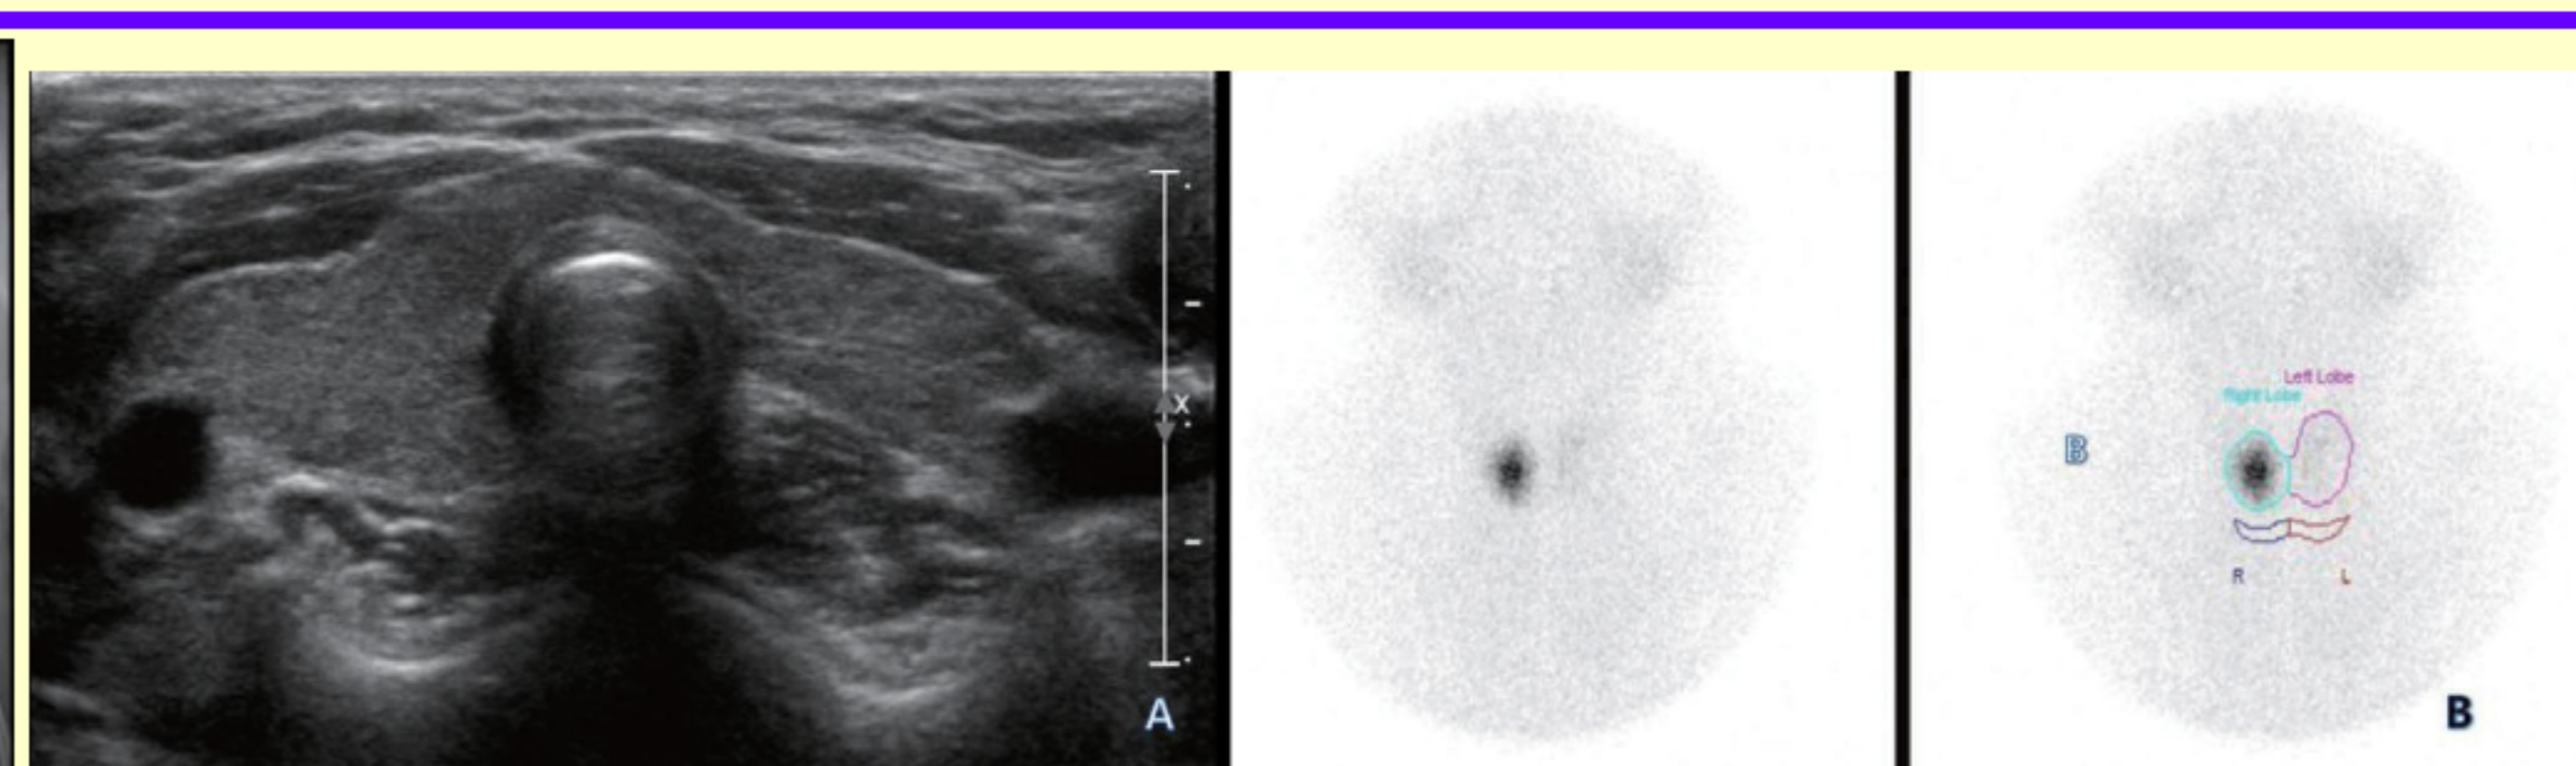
Thyroid ultrasonography showed mild heterogeneous echogenicity without intrathyroid nodule and lymph node enlargement (A), and thyroid 99mTc scintigram showed focal increase of radio-uptake in right lobe and nearly non-visualization of left lobe (B).
